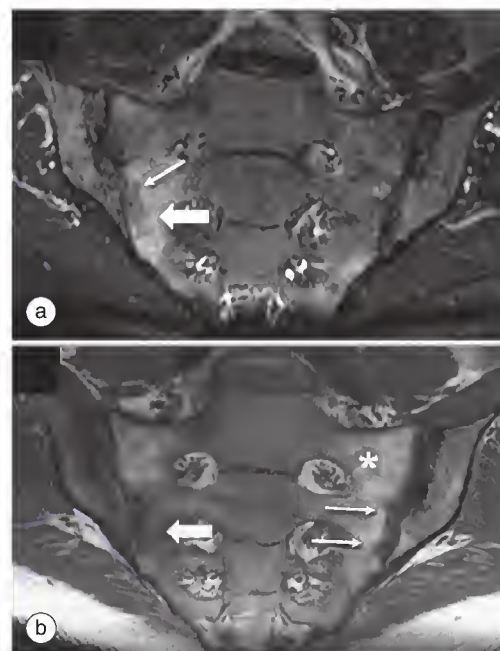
Magnetic resonance image (MRI) of the sacroiliac joints of a patient with ankylosing spondylitis. Bone marrow edema (osteitis) is visible as hyperintense signal in the short tau inversion recovery (STIR) sequence (a) and as hypointense signal (thick arrows) in the T1-weighted sequence (b). Postinflammatory changes such as fat deposition are visible as hyperintense signal in the T1-weighted sequence and hypointense signal in the STIR sequence (asterisk). Structural changes (erosions) are seen in both sequences (thin arrows). In cases where more than one inflammatory lesion or a large periarticular lesion is present on one slice, this MRI finding is highly suggestive of axial spondyloarthritis.
